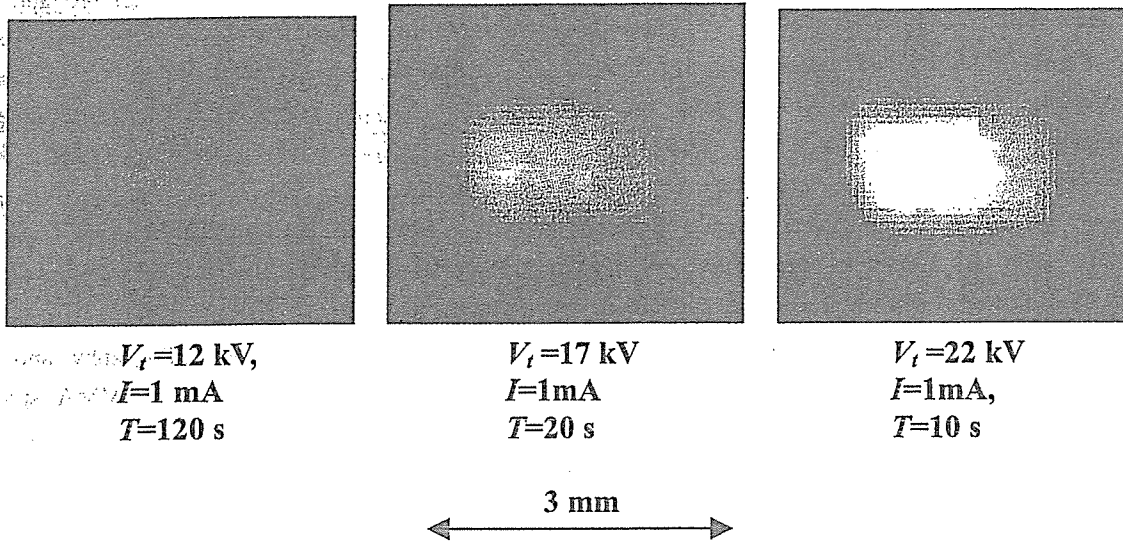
Images of the x-ray source measured by a 50- $\mu$ m-diameter pinhole with changes in the tube voltage.
